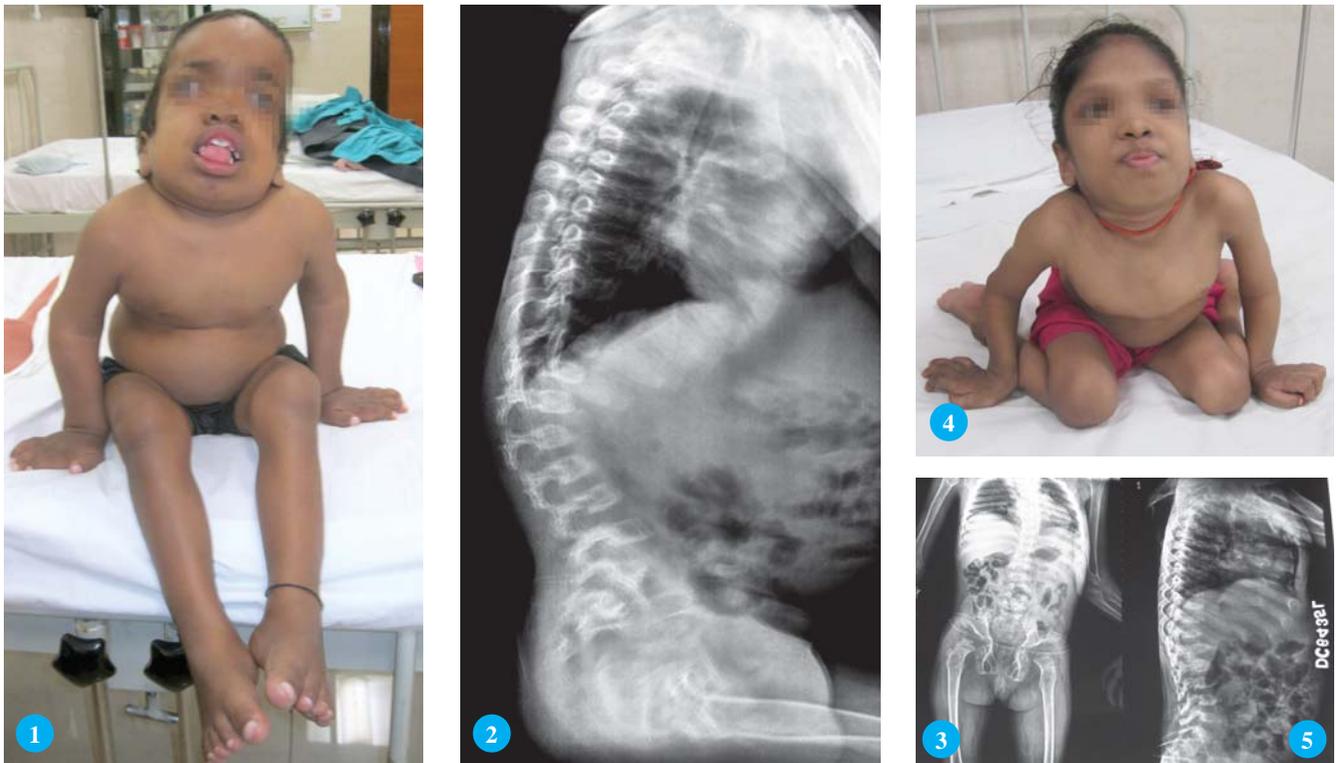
Showing Characteristic Facial Expression; Fig 2- Straight X-ray Skull Showing Anteroposterior Diameter more than Lateral; Fig 3- Straight X-ray Showing Dorsolumbar Kyphosis; Fig 4- Showing Facial Feature; Fig 5- Thoracolumbar Spine Showing Kyphoscoliosis
